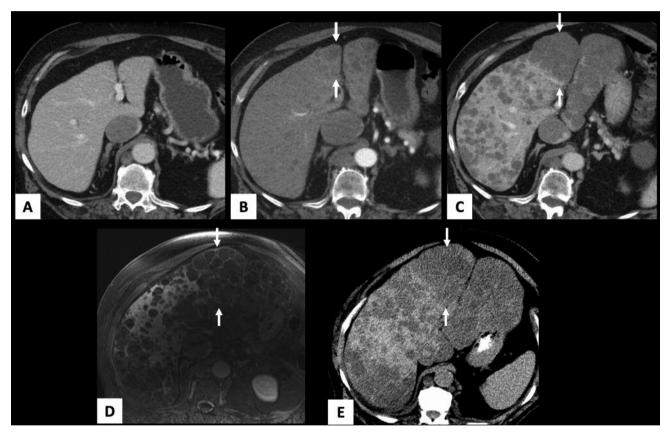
Enlarging cluster of cysts in segment IV of the liver bracketed by arrows growing over time. (A) Contrast-enhanced CT (CECT) with normal liver three months after RCC diagnosis. (B) CECT with small cysts seen as hypodense (darker structures) between arrows, 10 months after diagnosis. (C) CECT with hypodense cysts replacing parenchyma and expanding segment IV of the liver 19 months from RCC diagnosis. (D) CEMRI showing continued enlargement of the cysts 22 months after RCC diagnosis. (E) Non-contrast CT shows continued progression of cysts 24 months after RCC diagnosis.
